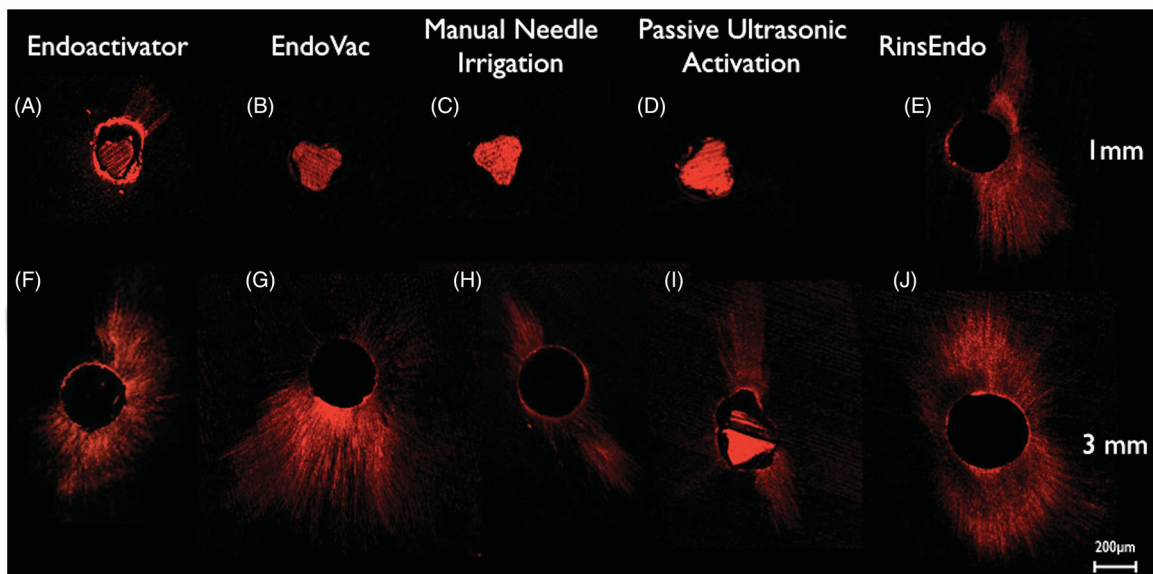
Representative CLSM images of experimental groups. Images were obtained by using a 10× objective. (A–E) Represents rhodamine B-labelled 2.5% NaOCl penetration at the 1-mm level after use of the Endoactivator, EndoVac, Manual Needle Irrigation, Passive Ultrasonic Activation, and RinsEndo systems, respectively, in the presence of an apically separated file. Limited NaOCl penetration could be observed with the use of EndoActivator at the 1-mm level from the apex in (A). A familiar cross-section of the ProTaper file could be seen at the centre of the root canal and there was no NaOCl penetration into the dentinal tubules in (B–D). A significant amount of NaOCl penetration into the dentinal tubules could be seen with the use of RinsEndo at the 1-mm level from the apex in (E). (F–J) represents rhodamine B-labelled 2.5% NaOCl penetration at the 3-mm level after use of the endoactivator, EndoVac, Manual Needle Irrigation, Passive Ultrasonic Activation, and RinsEndo systems, respectively, in the presence of an apically separated file. Different penetration depths and percentages could be observed with the use of these devices at the 3-mm level from the apex in (F–J).
